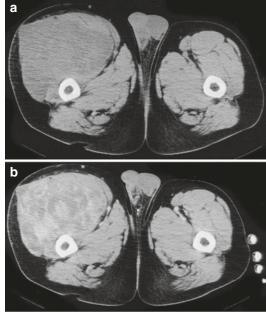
Liposarcoma of the thigh in a 68-year-old man. (a) Computed tomography (CT) scan. (b) After intravenous contrast medium. Mass arising in the right vastus intermedius muscle slightly hypodense to muscle on unenhanced CT (a) and irregularly enhancing after contrast administration (b)
